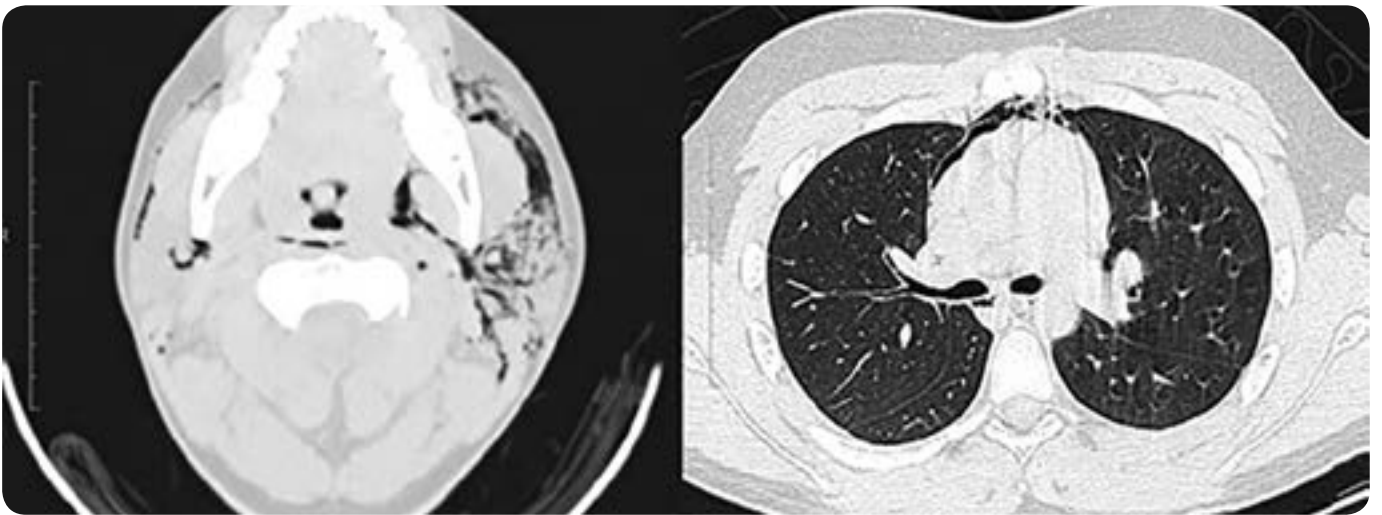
14-year-old patient with parotid pneumocele and associated pneumomediastinum. Axial CT cuts of neck and thorax: subcutaneous emphysema and air dissecting the parotid, parapharyngeal, mucosal and prevertebral pharyngeal spaces are observed, as well as air in the anterior and middle mediastinum.
